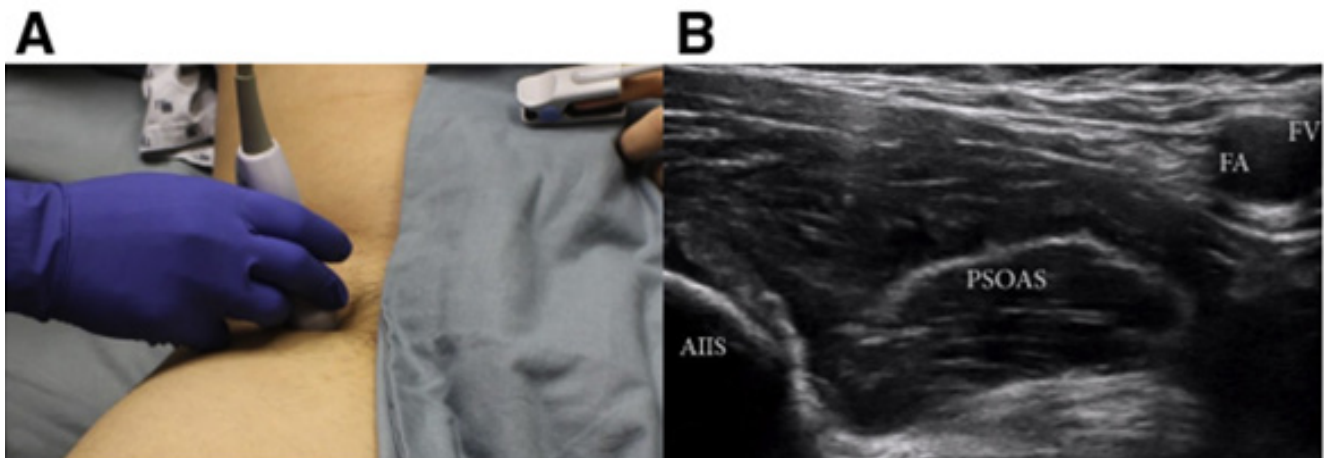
Position to perform the PENG lock. A. Probe aligned with the superior pubic ramus. B. Ultrasound view where key anatomical structures are labeled: Inferior Anterior Iliac Spine (AIIS), Femoral Artery (FA), Femoral Vein (FV), Psoas Muscle Tendon (PSOAS).
